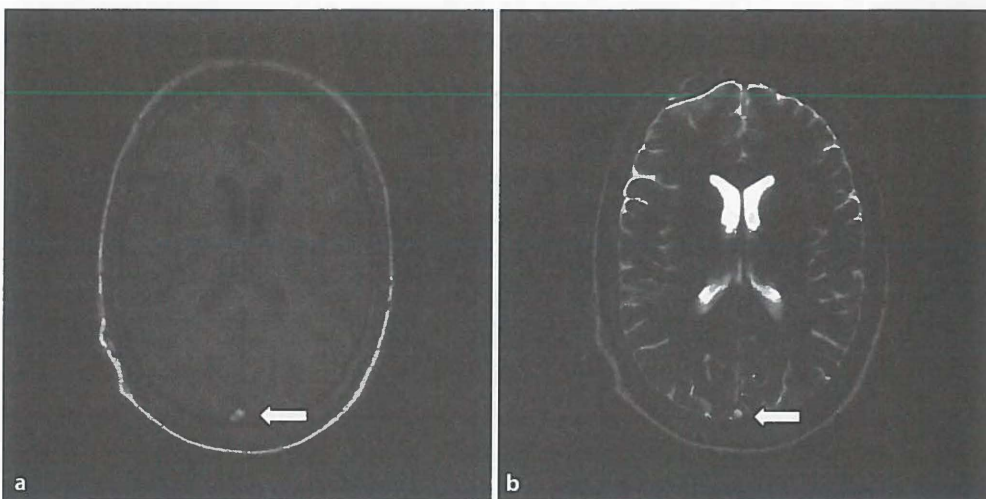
Subacute thrombus (arrow) in sagittal superior sinus appears hyperintense on T1-weighted image (a) and T2-weighted image (b)
